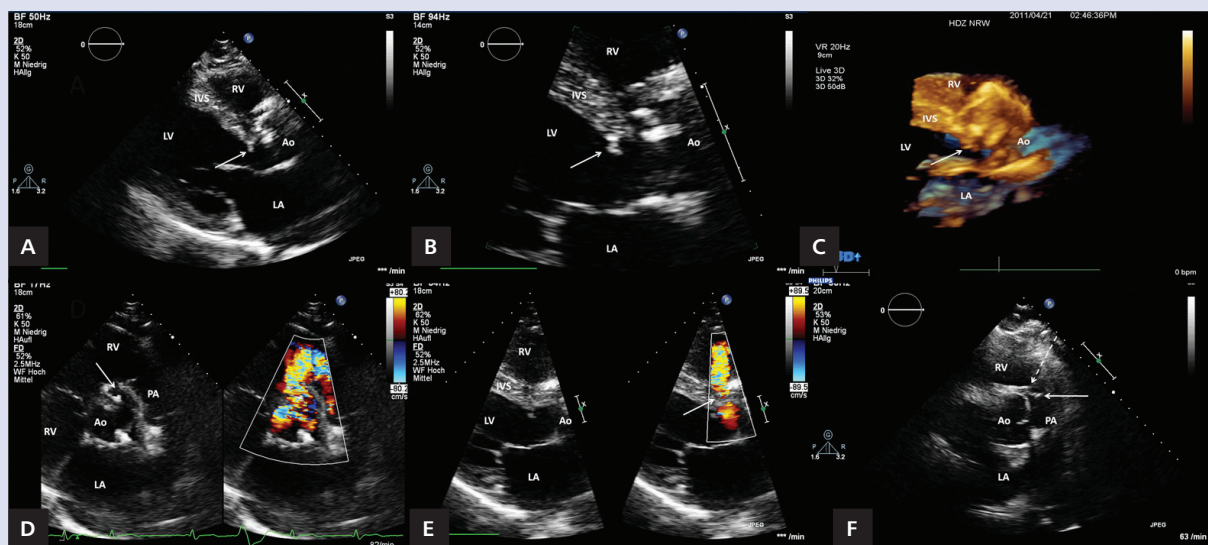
A–F. Transthoracic echocardiography; Ao — aorta; LA — left atrium; LV — left ventricle; RV — right ventricle; PA — pulmonary artery
